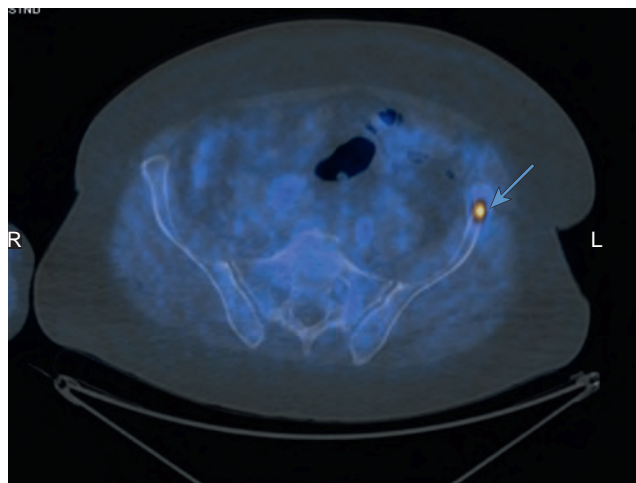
A choline positron emission tomography/computed tomography scan showing bony pelvic metastasis in a man with radiorecurrent prostate cancer.
